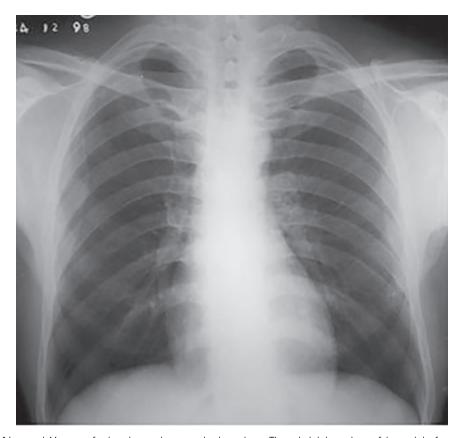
Normal X-ray of chest, postero-anterior view. The right border of heart is formed by the superior vena-cava and right atrium. The left border is formed by the aorta, main pulmonary artery, left atrial appendage, and anterolateral border of the left ventricle.
